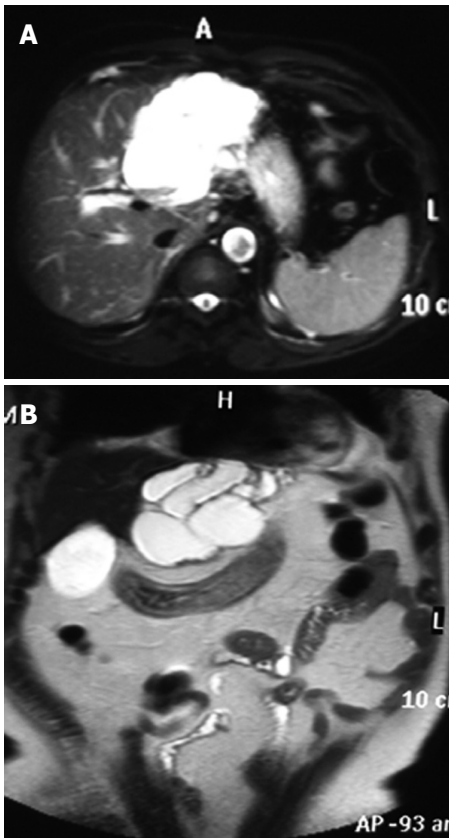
Biliary cystadenocarcinoma. A and B: Magnetic resonance imaging (MRI) scans showing a multilocular cyst in the left lobe of the liver.
